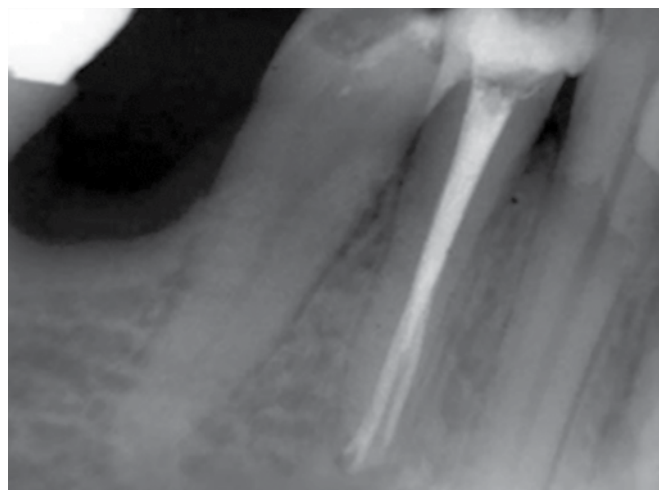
Final radiograph showing the obturation of three root canals
